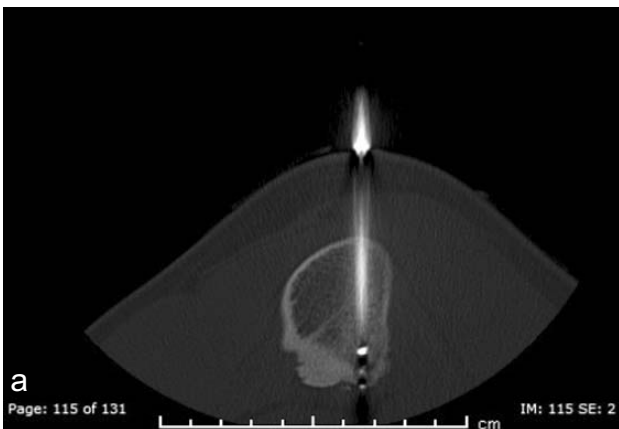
(a,b): End of MWA guide-wire passed inside the nidus under CT guidance, through which microwaves are introduced.
